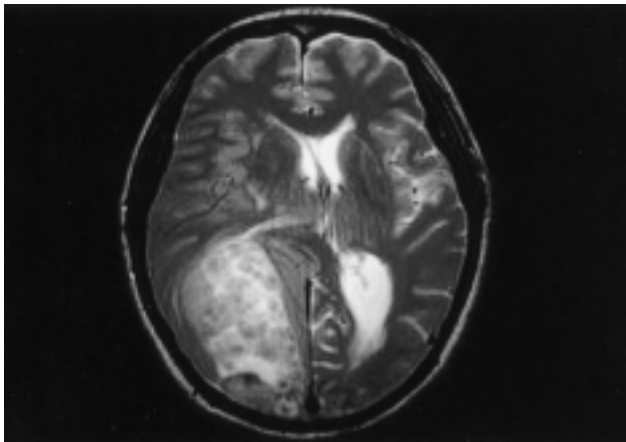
Magnetic resonance image demonstrates a heterogeneous high T2 weighted signal.
